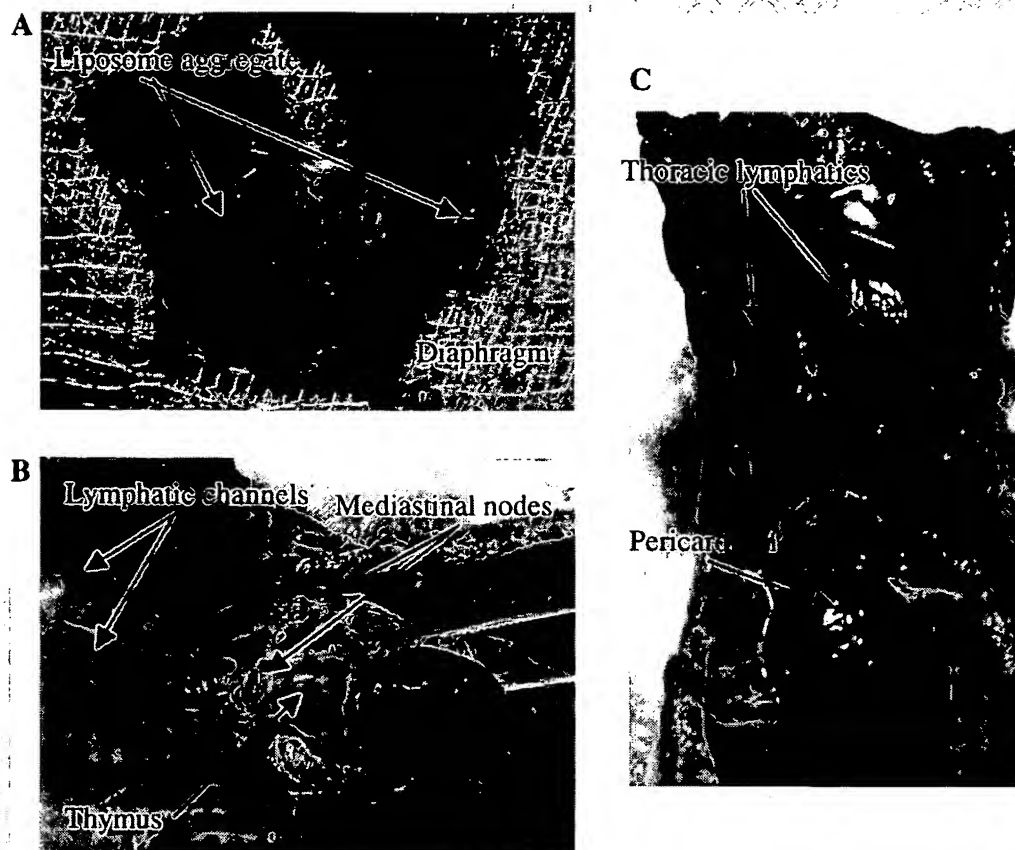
(A) Photograph of the diaphragm and the pleural lymphatics that cover the upper part of the diaphragm showing the accumulation of blue-liposome aggregate; (B) photograph of the mediastinal nodes and the parasternal lymphatics channels that drain the upper part of the diaphragm into mediastinal nodes; (C) Photograph showing the accumulation of blue-liposome aggregate in the pericardial lymphatics and the thoracic lymphatics at the chest wall that drain pleural space.
